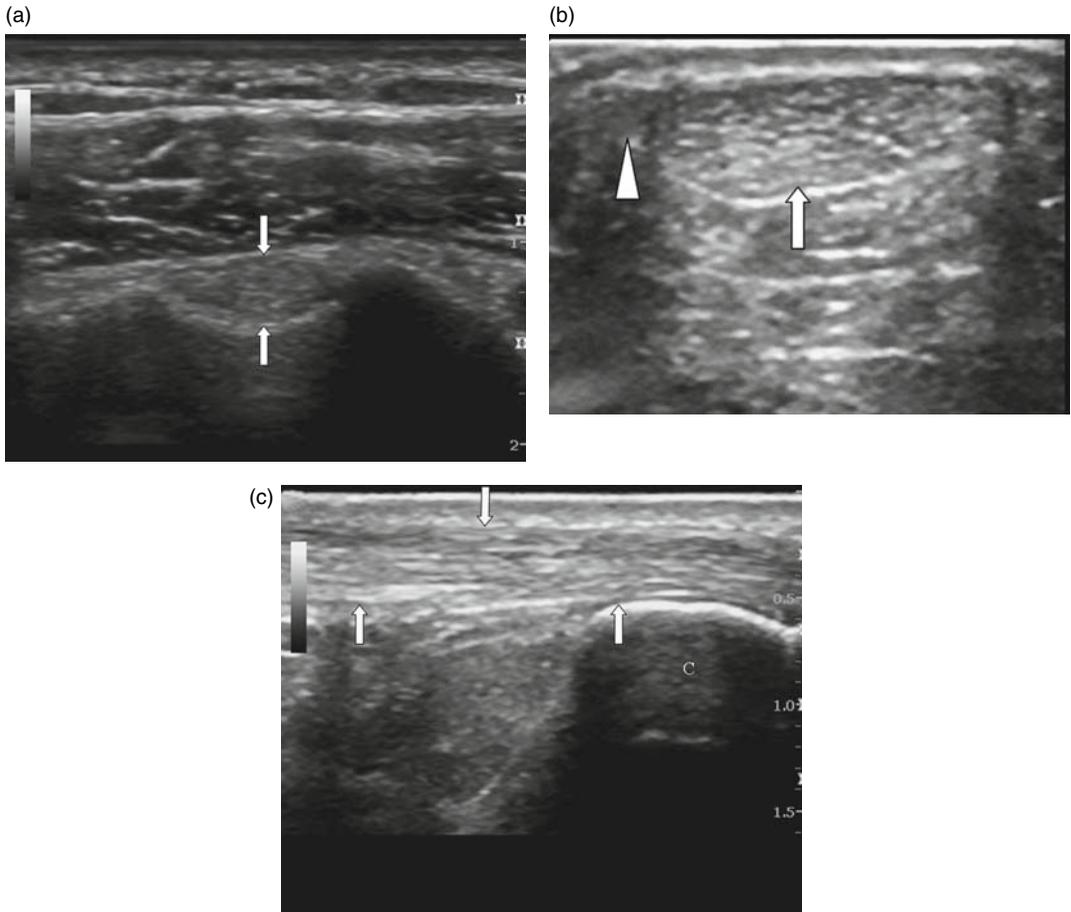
(a) Transverse ultrasound image of the hyperechoic round long head biceps tendon (arrowhead) within the bicipital groove. (b) Achilles tendon (AT) transverse ultrasound image of the oval AT: (arrows) and adjacent plantaris tendon (arrowhead) medially; the paratenon is identified as the thin hyperechoic rim surrounding the AT. (c) Longitudinal ultrasound at (arrows). C, calcaneus.
